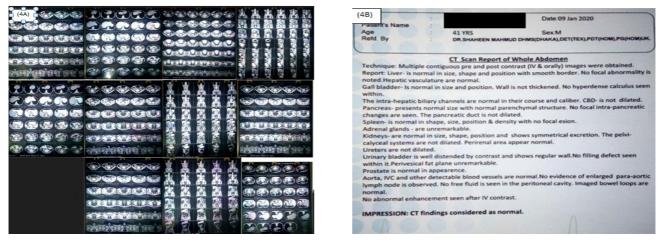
4A) CT abdomen dated 9/1/2020; 4B) Findings: Normal CT scan.
